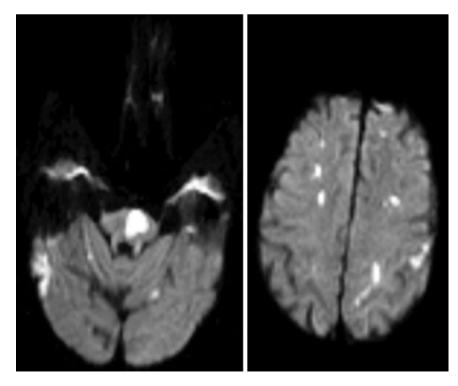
Diffusion-weighted MRI of cholesterol emboli after combined coronary artery bypass grafting and aortic valve replacement. The patient was slow to awake with right hemiparesis, right gaze deviation, purple toes, and renal failure. The preferential distribution of emboli to distal vascular territories can be seen.
